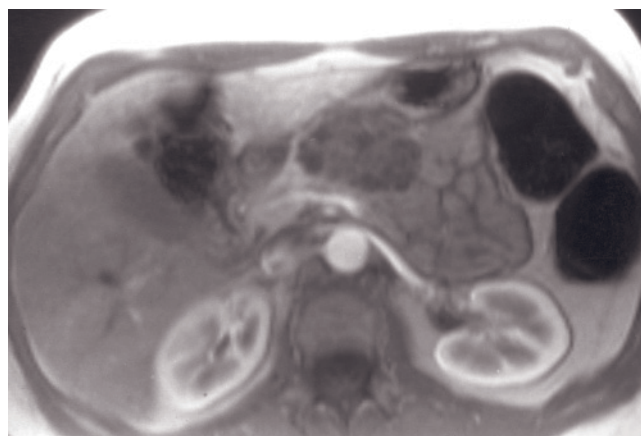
Serous cystadenoma. T2-weighted SS-ETSE (a), fat-suppressed T1-weighted gradient-echo (b), and immediate (c) and interstitial-phase (d) postgadolinium fat-suppressed T1-weighted gradient-echo images demonstrate a cystic mass in the pancreatic head. The lesion is well defined and low in signal intensity in a background of high-signal-intensity pancreas. On the T2-weighted image (a), definition of fine septations (black arrows, a) within the cystic mass (white arrows, a) reveals that the cysts are <1 cm in diameter. The serous cystadenoma is high in signal intensity on T2-weighted images (a), reflecting their high fluid content.
